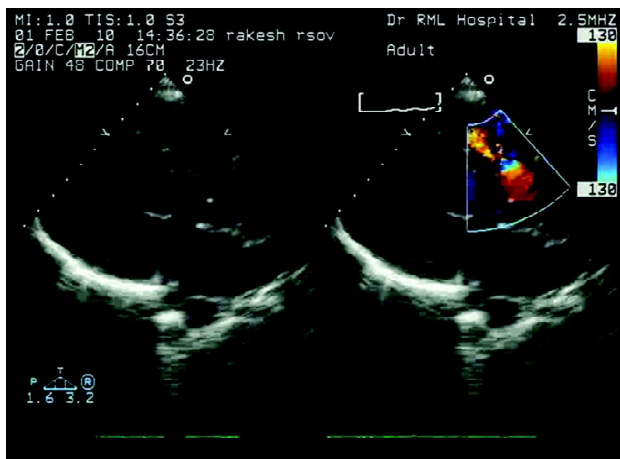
Parasternal long axis view showing colour Flow through the defect.
